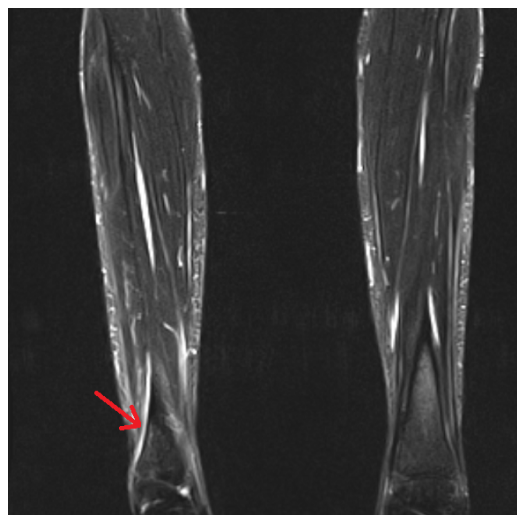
Magnetic resonance imaging before treatment with tocilizumab.
